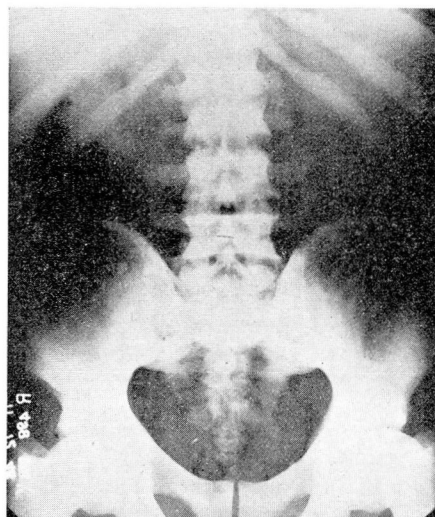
Roentgenogram of the lumbar region of the spine and pelvis.
